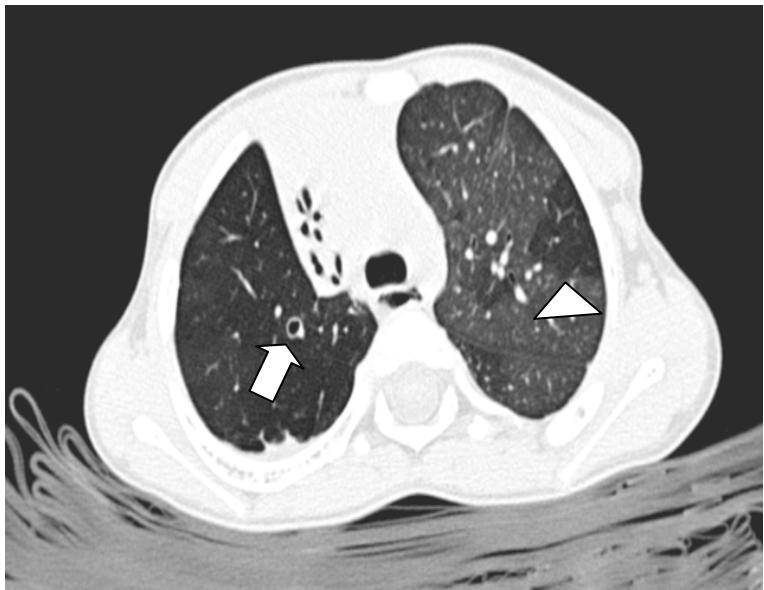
3 years-old girl with severe BPD. Inspiratory axial CT showing regional attenuations (arrowheads). The pulmonary vessels caliber in those areas are smaller. Bronchiectasis (white arrows) are also noted.
